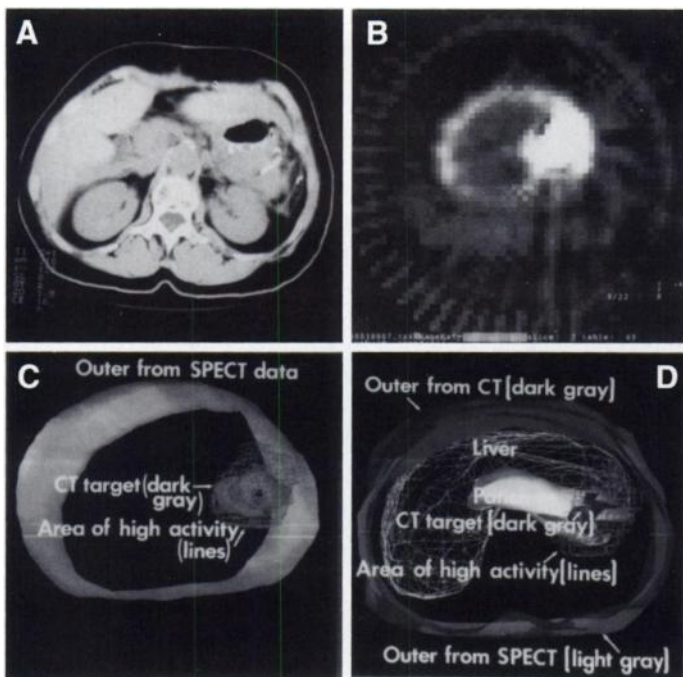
(A) CT image of a patient with pancreatic disease shows position of the needle at ^{32}P injection site. (B) SPECT transverse image of the same patient after injection of ^{32}P shows area of high activity. (C) Three-dimensional representation of the patient's outer surface and the iso-count distribution determined from SPECT superimposed with the target from CT. (D) Co-registration of three-dimensional structures.
